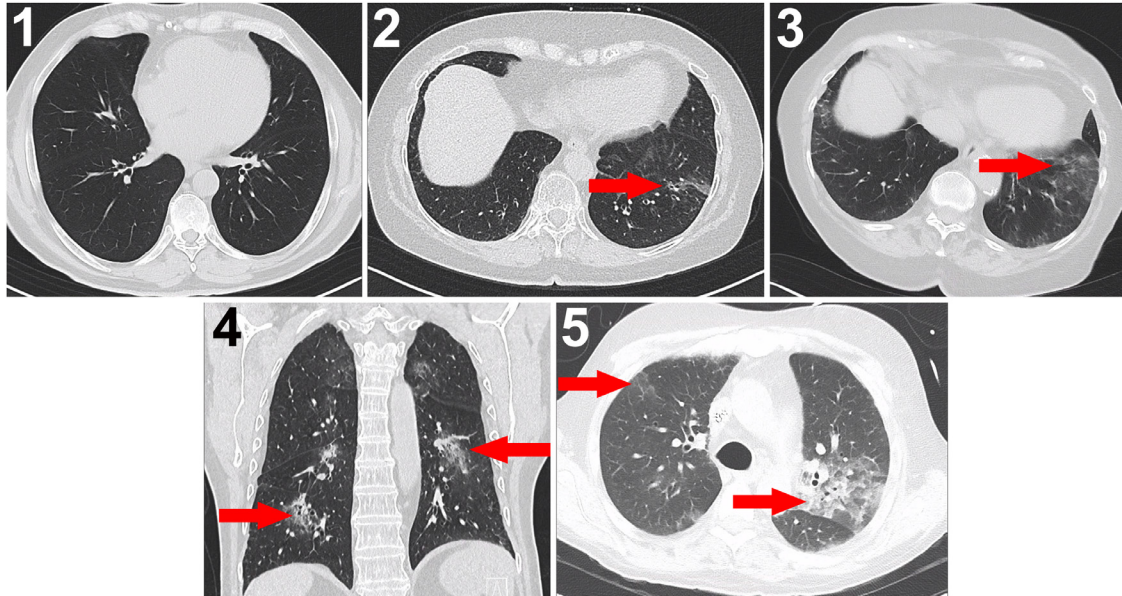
Examples of all 5 CO-RADS categories (1 = very low suspicion, 2 = low, 3 = unsure, 4 = high and 5 = very high suspicion). 1: no abnormalities. 2: thickened bronchial walls and tree-in-bud feature, not typical for COVID-19. 3: Unilateral ground glass lesion in the lower left lobe. 4: bilateral multifocal ground glass opacities, but not in close contact with the visceral pleura. 5: Bilateral ground glass opacities with peripheral distribution. The red arrows indicate the location of the abnormalities. CO-RADS score = a score system developed by the Dutch radiological society (NIVR) categorizing chest CT images based on the likelihood of COVID-19. COVID-19, Corona virus disease 2019.
